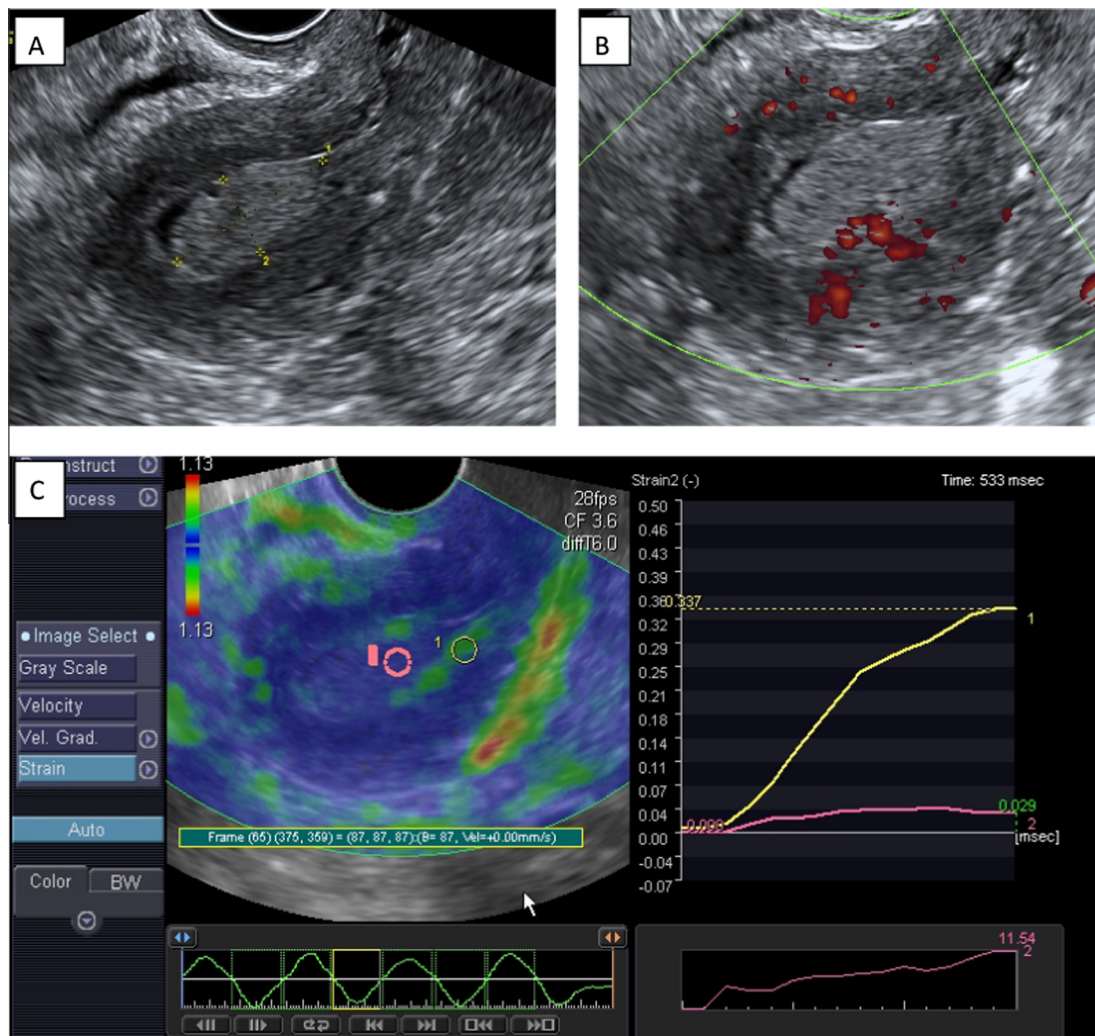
Ultrasound images of a female patient, aged 55 years with malignant thickened endometrium (confirmed to be endometrial adenocarcinoma by pathological examination). B-mode ultrasound image (A), Power Doppler image (B) and TV elastogram (C) show endometrial thickness = 18 mm with increase vascularity, dark blue color and SR = 11.54.
